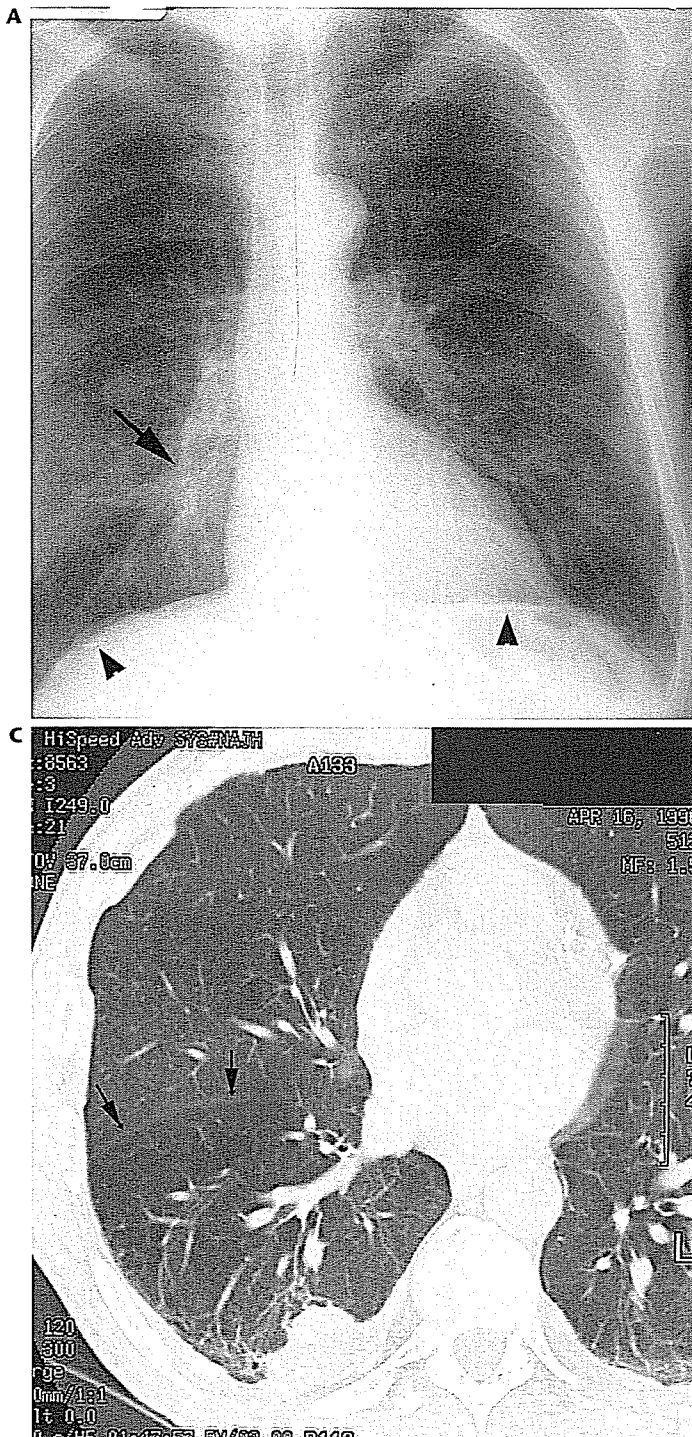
Rounded atelectasis. A, Frontal chest radiograph shows a subtle increase in density on the right (arrow). Linear plaque calcification is evident along each hemidiaphragm (arrowheads). B, Lateral chest radiograph shows a rounded mass along the posterior pleura (arrows). C, CT shows a rounded mass adjacent to an area of pleural thickening, with a vessel curving into its lateral aspect. Lobar volume loss is evident from the posterior displacement of the major fissure (arrows).
